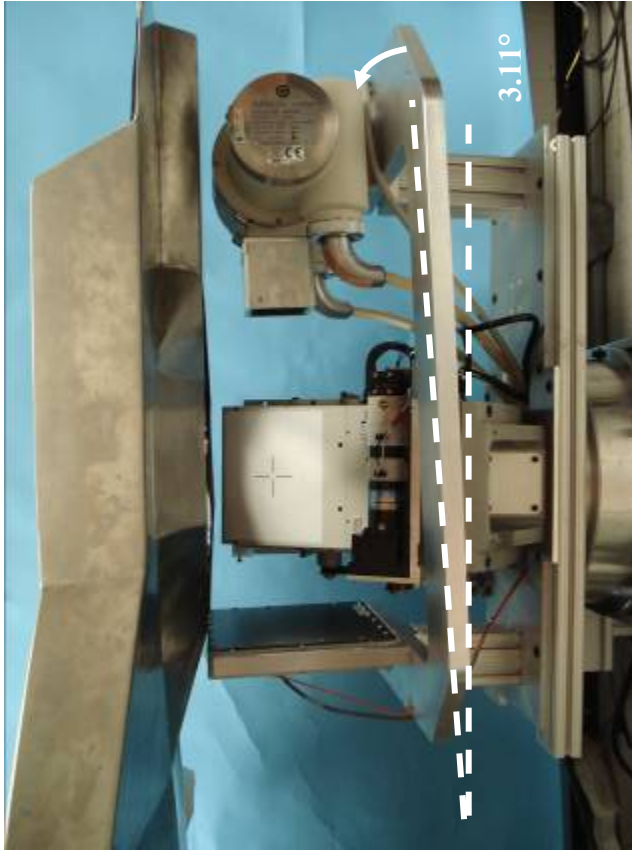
(Left) CAD image of the u-arm based CT system and (right) photograph of the new integrated CT system design tilted at 3.11° such that the tops of the x-ray source and detector are co-planar. The modeled x-ray source (left) is a CAD model obtained directly from Varian and so the vertical orientation of the anode and cathode terminals in the modeled x-ray tube are fixed and different from the orientation of the anode and cathode shown in (right) the implemented integrated SPECT-CT system.
